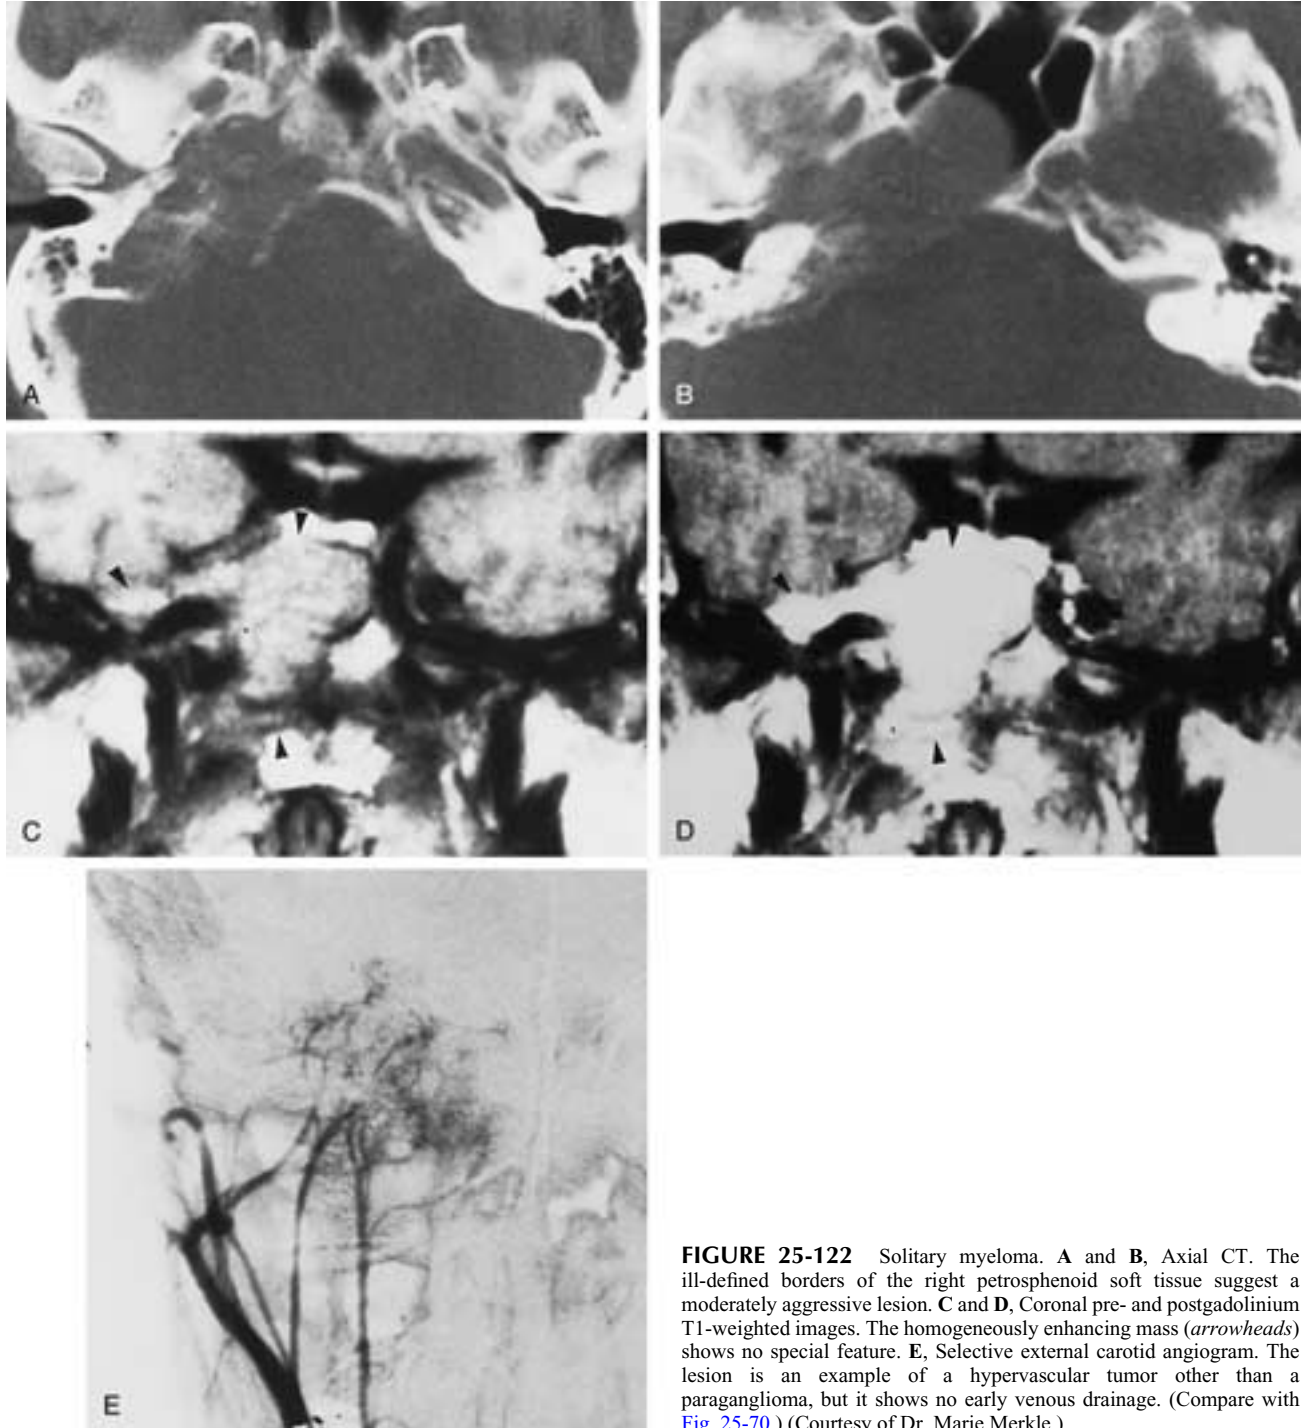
Solitary myeloma. A and B, Axial CT. The ill-defined borders of the right petrosphenoid soft tissue suggest a moderately aggressive lesion. C and D, Coronal pre- and postgadolinium T1-weighted images. The homogeneously enhancing mass (arrowheads) shows no special feature. E, Selective external carotid angiogram. The lesion is an example of a hypervascular tumor other than a paraganglioma, but it shows no early venous drainage. (Compare with Fig. 25-70.) (Courtesy of Dr. Marie Merkle.)
